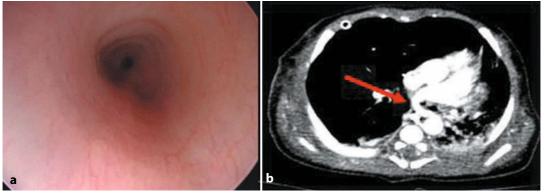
Tracheal stenosis. Endoscopic view (a). CT showing pulmonary artery sling (b)
